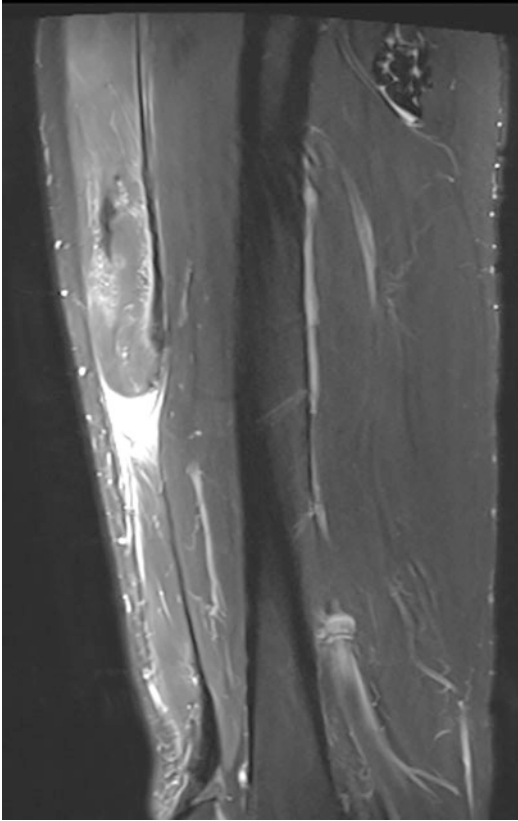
A complete rectus femoris mid-substance rupture in MRI
